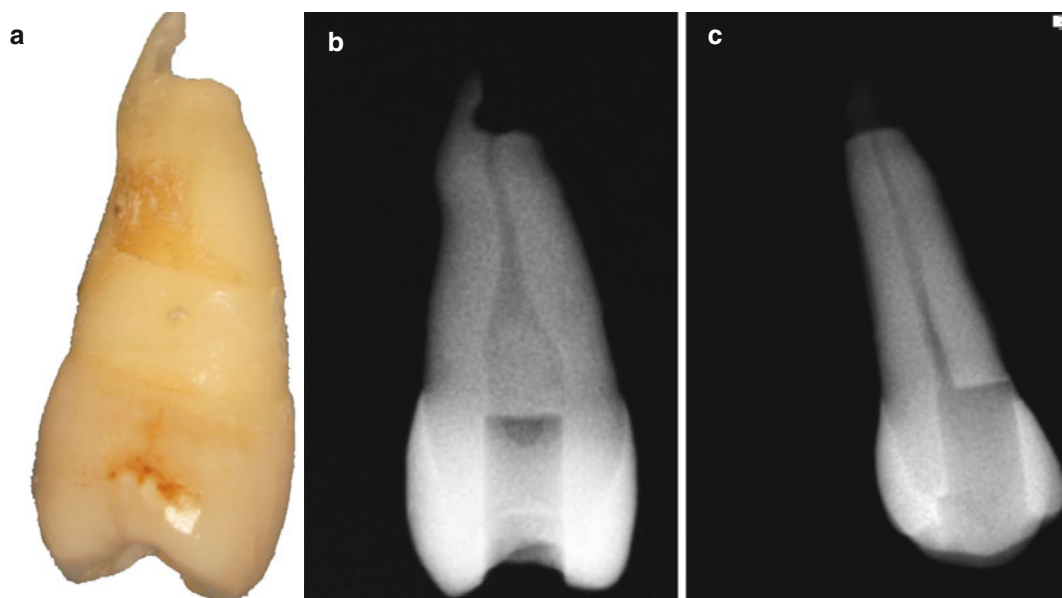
Incomplete root-end resection (a). While it is seen on the mesio-distal radiograph (b), the incomplete root-end resection is not visible on a bucco-lingual radiograph (c)
